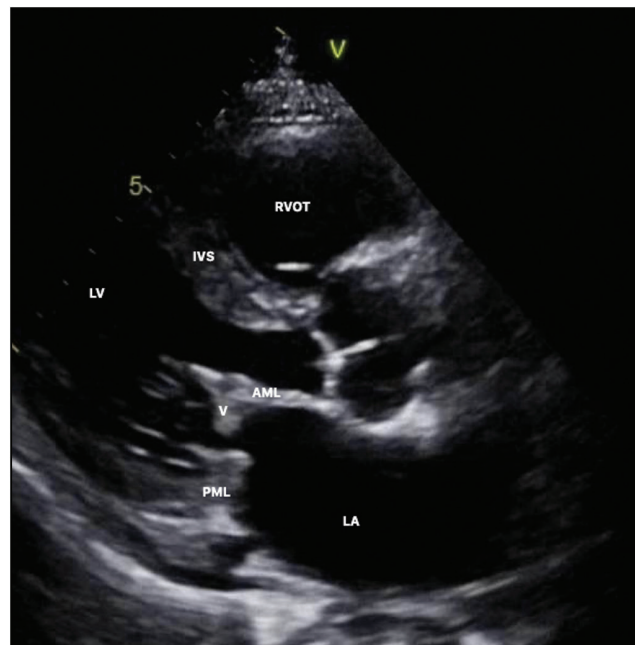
Transthoracic echocardiogram, parasternal long access view showing the vegetation on the anterior mitral leaflet. AML = anterior mitral leaflet, IVS = interventricular septum, LA = left atrium, LV = left ventricle, PML = posterior mitral leaflet, PW = posterior wall, RVOT = right ventricle outflow tract, V = vegetation
